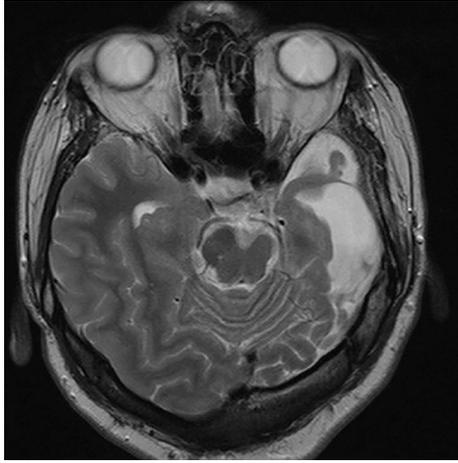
A 17-year-old female patient with cerebral hemiatrophy and parenchymal volume loss in the left half of the brainstem compared to the right (T2 weighted MRI).
